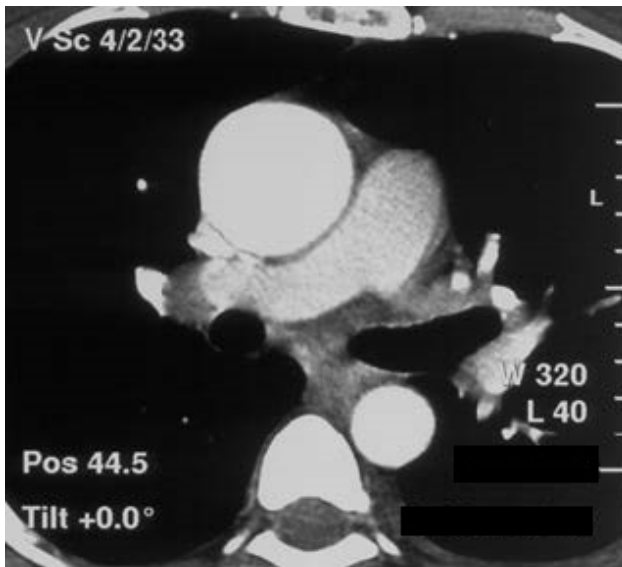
Contrast enhanced spiral CT scan in a 43 years old female patient with acute pulmonary thromboembolism and thrombophilia reveals a full filling defect in the right pulmonary artery
